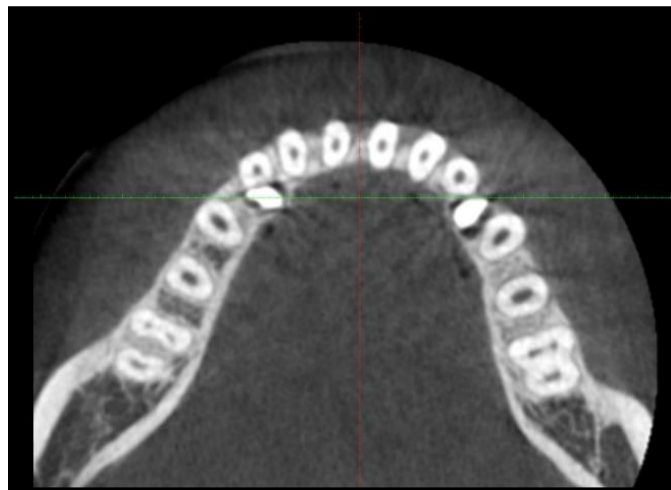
CBCT examination of the lower arch
